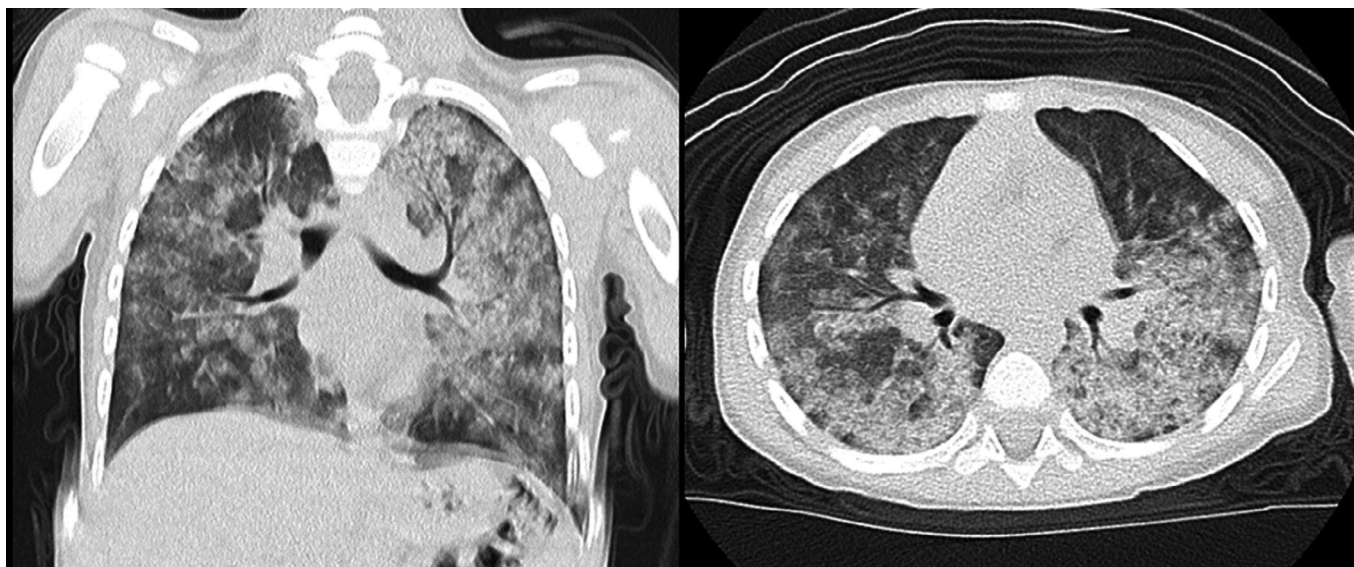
Computed tomography scan of the chest showing diffuse alveolar infiltrates with ground-glass opacities.
